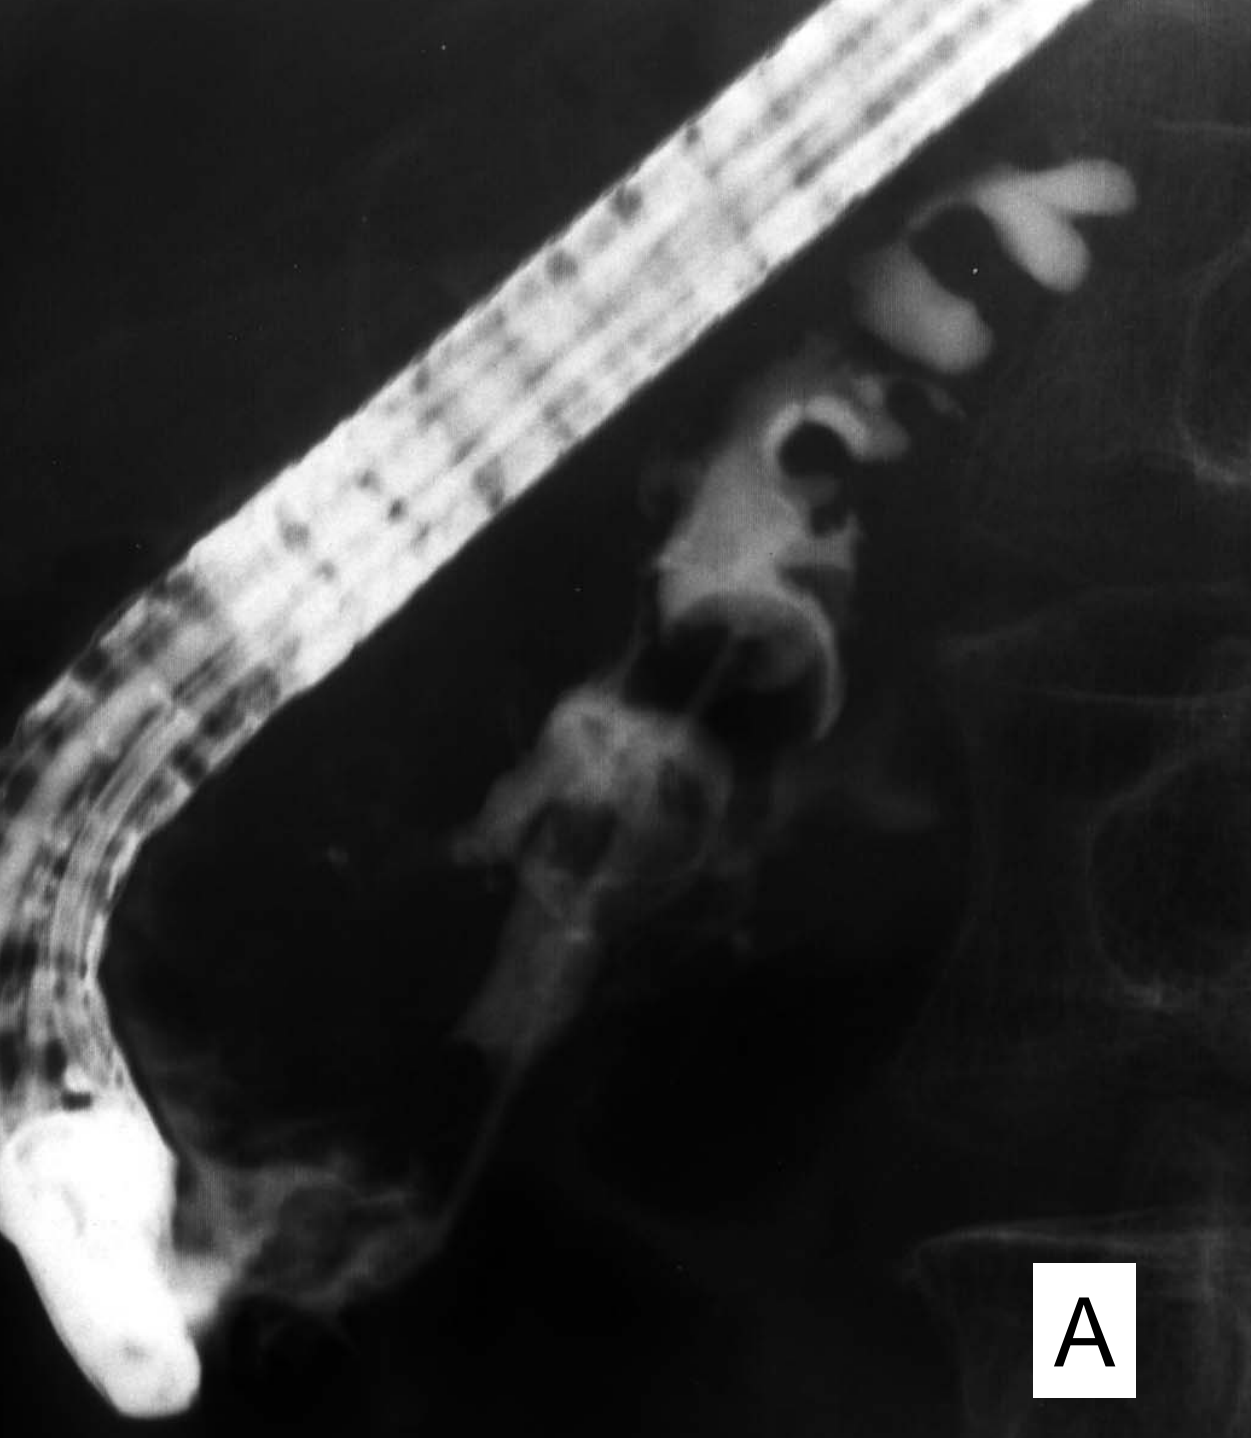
(A) Endoscopic retrograde pancreatography of the remnant pancreas shows a marked dilatation of the main pancreatic duct with mural nodules (patient 4). (B, C) CT also shows a marked dilatation of the main pancreatic duct.
